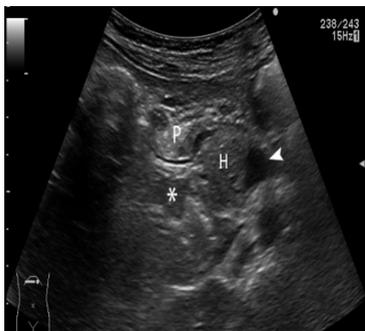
Transverse oblique post-operative ultrasound image showing the normally-located pylorus (P) and duodenal bulb (asterisk) on the right of the head of the pancreas (H) (arrowhead showing the portal vein).
